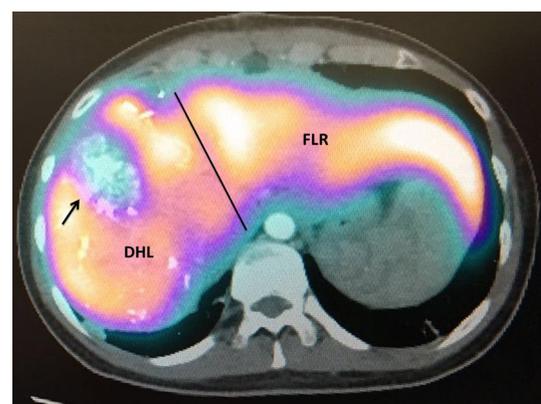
Liver HIDA scintigraphy with SPECT CT fused image before the stage 2. Axial section in a 30-year-old patient with multiple liver metastases from sigmoid colon tumor. The *black arrow* showed tumor in the disease hemiliver (DHL). The *black line* showed the limits of the transection line. The future liver remnant (FLR) function was 41 %. sFLR (standardized future liver remnants): 31 %. FLR/BW (body weight): 0.69 %
